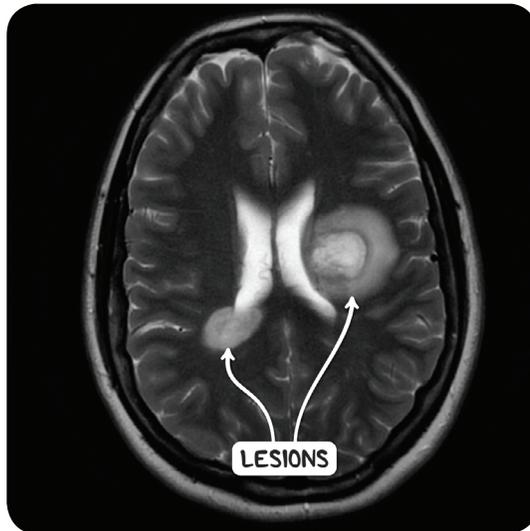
An MRI scan of the head of an individual with acute disseminated encephalomyelitis. There are bilateral, asymmetrical, tumefactive lesions of the cerebral white matter.
